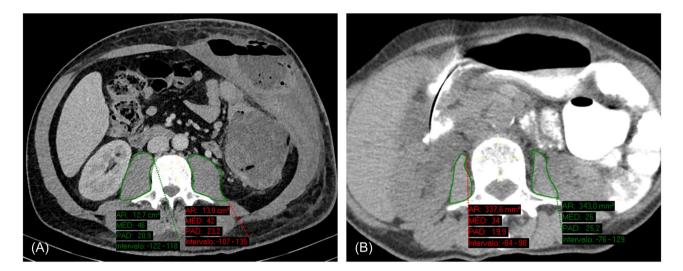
Computed tomography images at the L3 vertebral body showing the total psoas area measurements by the Junior surgeon in non-sarcopenic (A) and sarcopenic cases (B).
